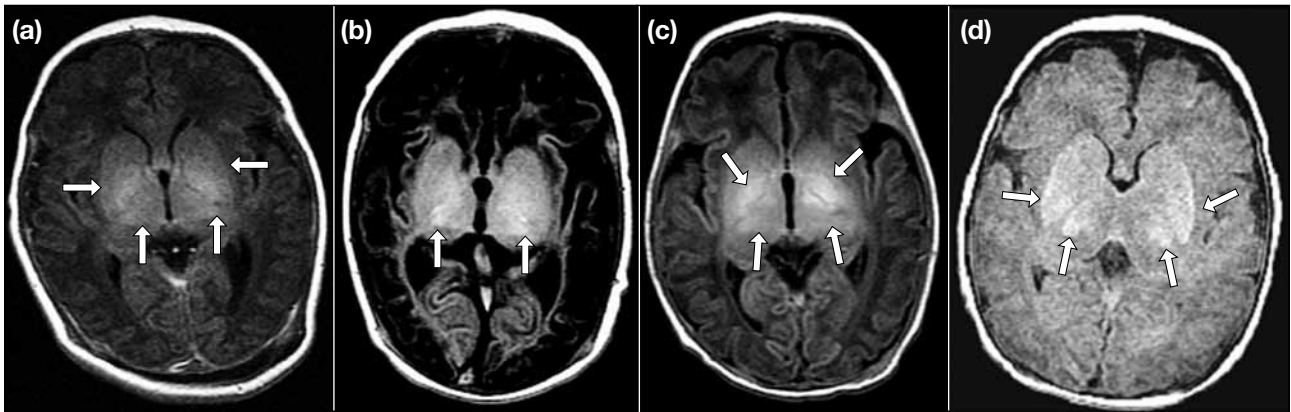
Spin-echo T1-weighted magnetic resonance imaging of the basal ganglia and thalami (arrows) showing (a) normal signal, (b) mild change (subtle focal abnormality, most frequently in the ventrolateral nuclei of the thalami and / or posterior putamen), (c) moderate change (multifocal discrete areas of damage or more diffuse abnormal signal intensity involving different regions), and (d) severe change (widespread abnormal signal intensity involving the entire region, with or without caudate nuclei involvement).
